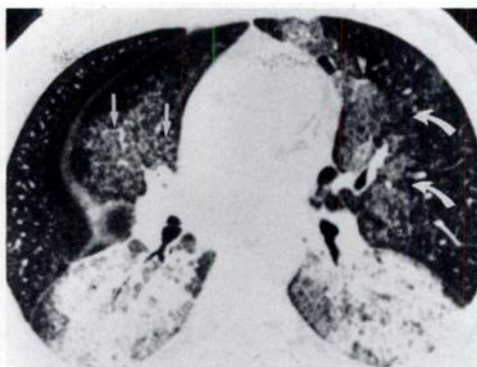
Alveolar proteinosis. High-resolution CT scan shows dense consolidation of both lower lobes with patchy and confluent areas of ground-glass opacity best seen in lingula (curved arrows). Ground-glass opacity is due to alveolar filling with proteinaceous material rich in lipid. Interstitial thickening due to edema (after recent lavage) or fibrosis is evident in right middle lobe (straight arrows).
